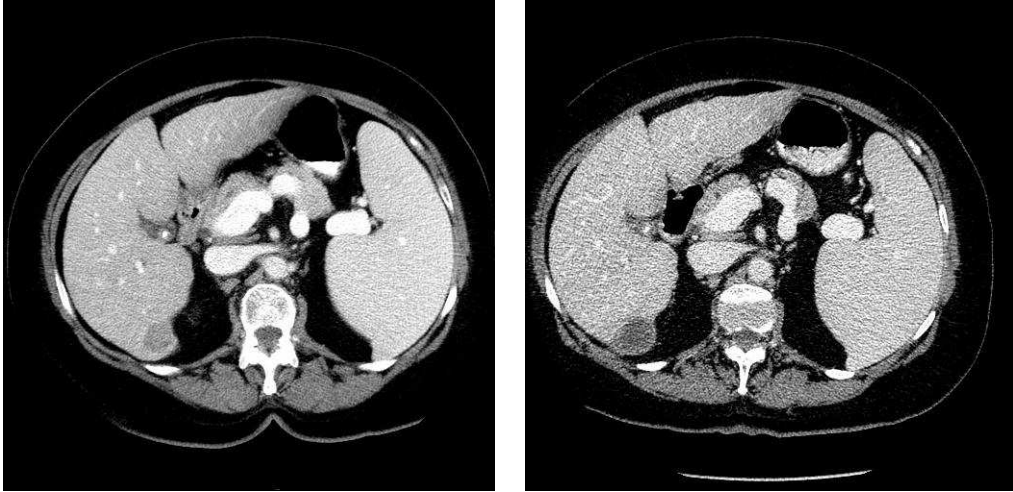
Pre and post RFA treatment CT images
